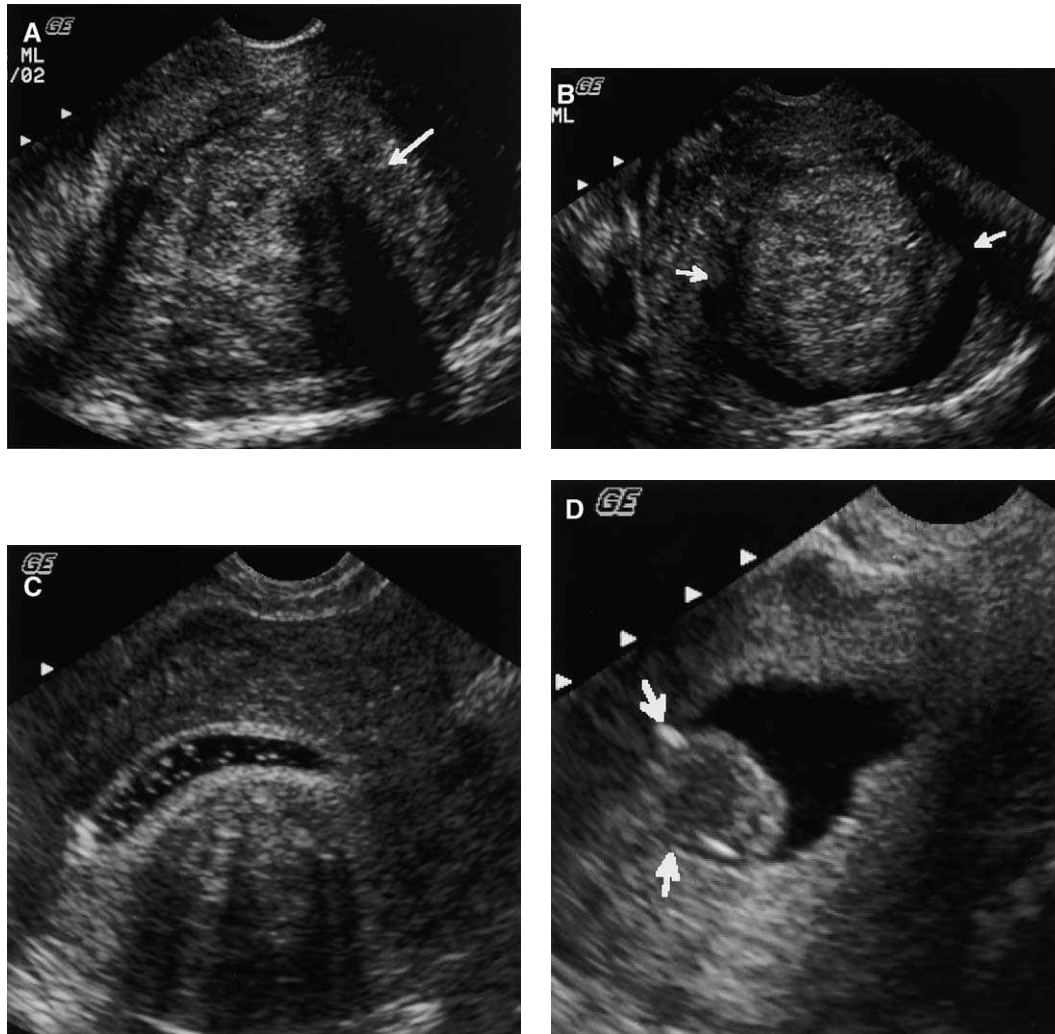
(A) Coronal transvaginal ultrasound in 47-year-old woman with heavy menses demonstrates a centrally located fibroid (arrow). (B) SHG shows that this fibroid projects approximately 50% of its total volume into the endometrial cavity (arrows). (C) Coronal SHG in a 32-year-old woman with dysfunctional uterine bleeding shows a submucosal fibroid with less than 50% protrusion into the endometrial canal (arrows). (D) Sagittal SHG in a 47-year-old woman with postmenopausal bleeding demonstrates a submucosal fibroid with more than 50% protrusion into the endometrial cavity (arrows).
